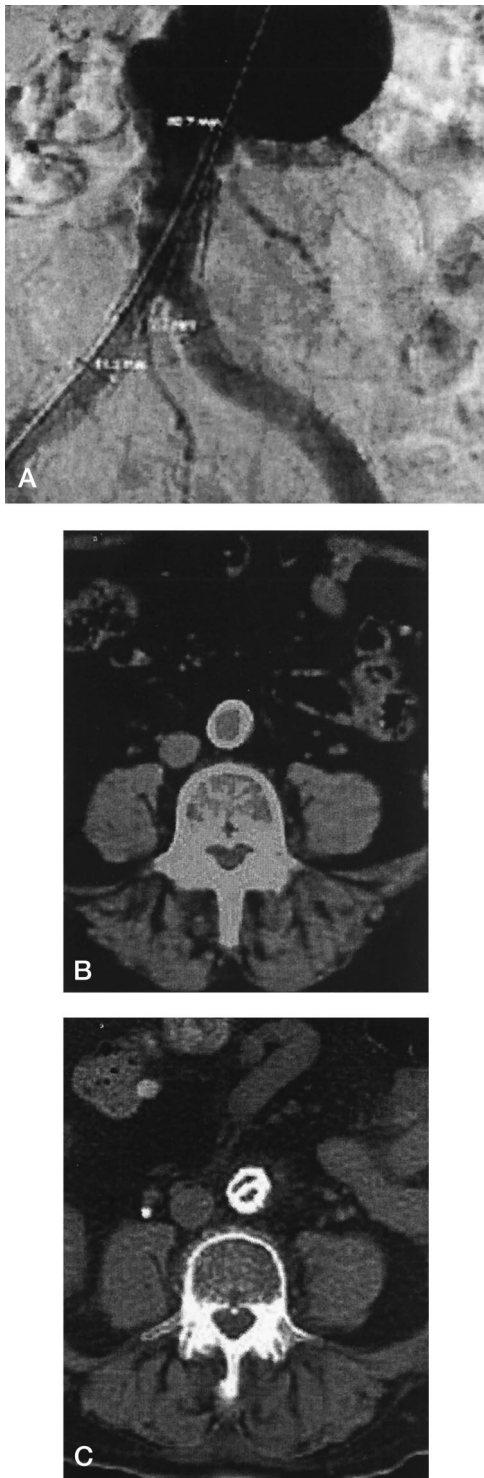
A, Preoperative angiogram showing a narrow, calcified distal aorta. B, CT of the distal aorta, showing heavy calcification. C, CT 6 months after endovascular repair, showing the two graft limbs within the distal aorta. Both limbs contain Palmaz stents; hence, their D-shaped cross-sectional profile. The graft lumens are actually larger than they appear, due to the stent artifact, and the patient has normal femoral pulses.
